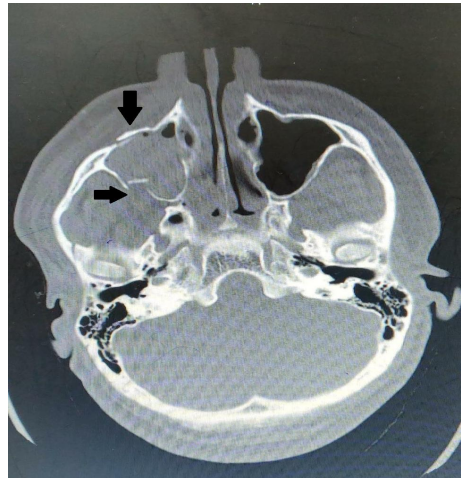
CT axial section showing fracture of anterior and posterolateral wall of maxillary sinus with right haemosinus
